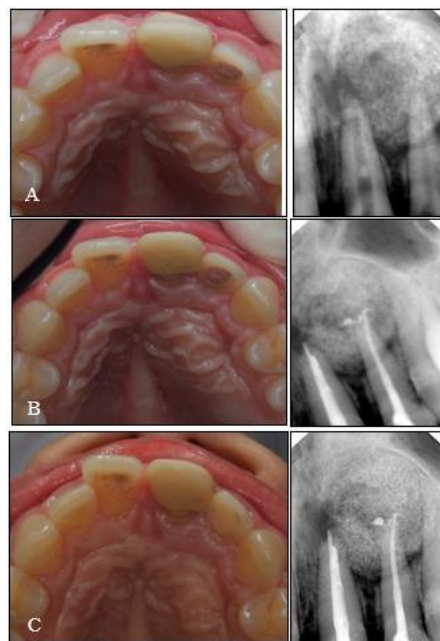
Clinical and Radiographic view after post-surgery (A) 1 month, (B) 3 months, (C) 6 months
